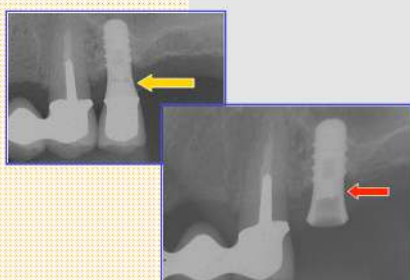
Abutment fracture. The fracture seen on the X-ray (arrow). The fractured portion remained in the implant (red arrow).
